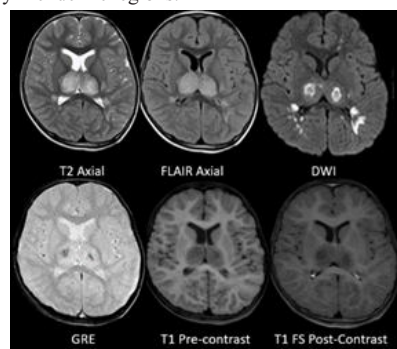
Case of a 17-year-old male patient with dengue hemorrhagic fever, MRI shows T2W/FLAIR hyperintensity with corresponding T1W hypointensity and diffusion-restriction in the bilateral thalamus with blooming on the GRE sequence with surrounding edema, manifesting as the characteristic “Double Doughnut Sign.”
